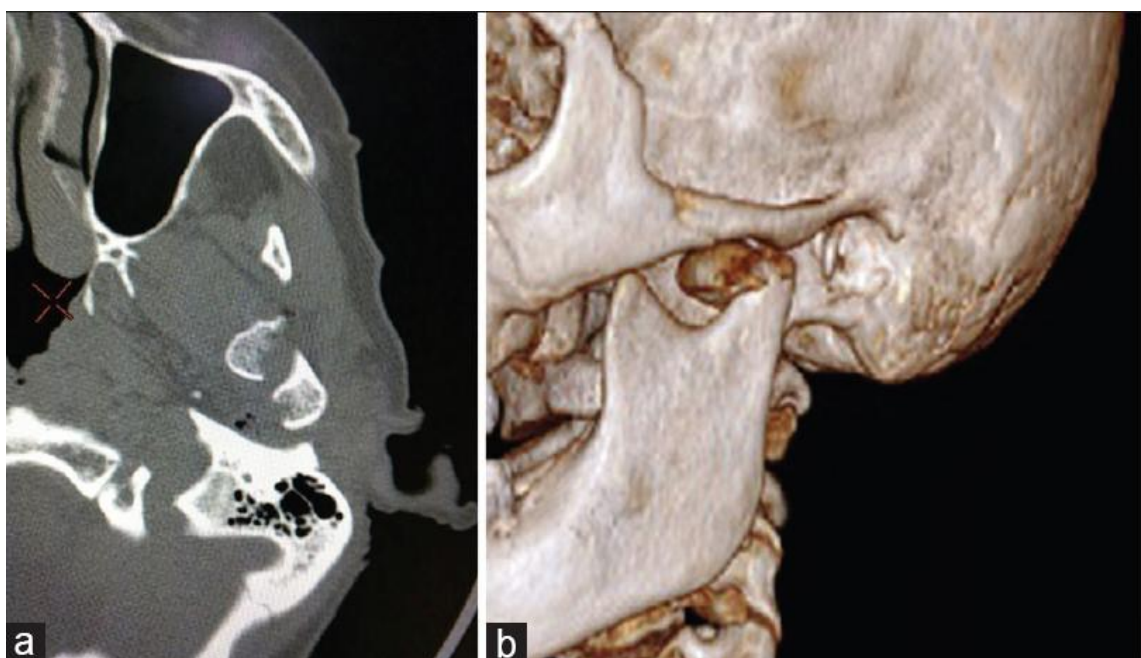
2 (a) Axial computed tomography images showing fracture of the left condylar process of the mandible. (b) Three-dimensional rendered images showing better appreciation of the displaced fracture fragment of the left condylar process in the infratemporal fossa
